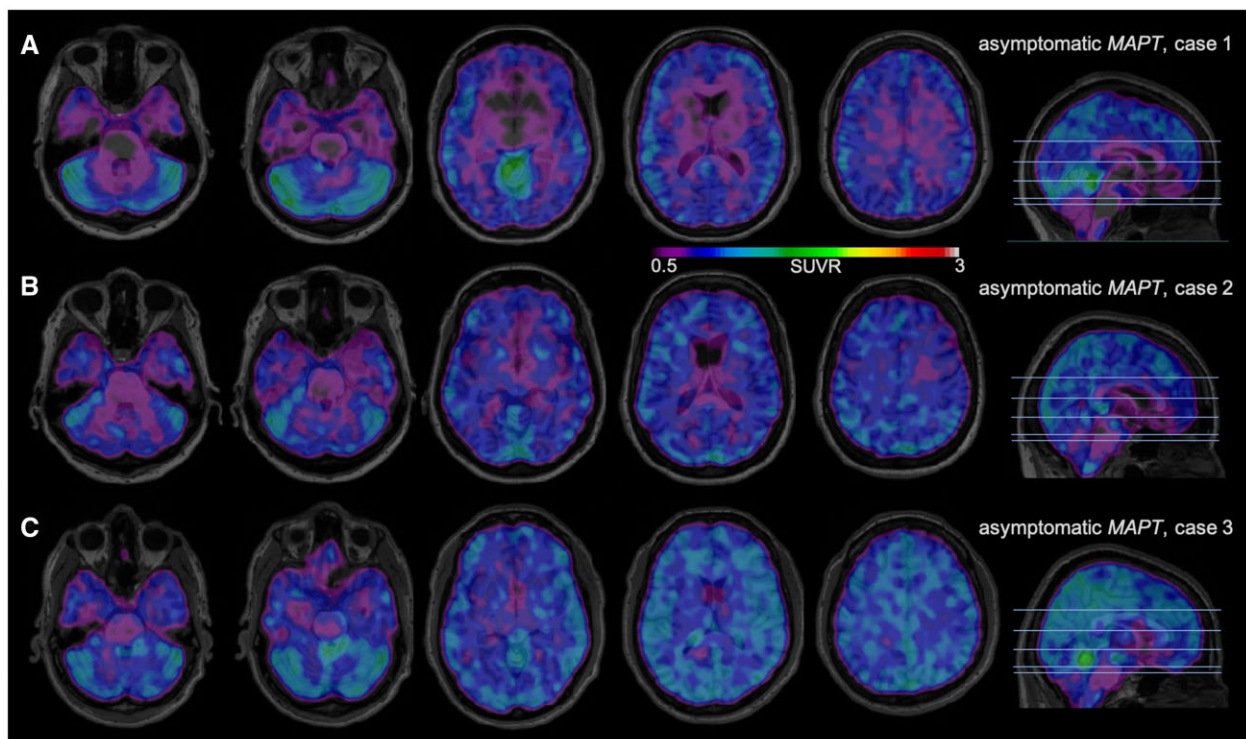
¹⁸F-MK-6240 tau-PET scans in presymptomatic MAPT mutation subjects. A higher SUVR represents stronger binding. Binding to meninges, including the tentorium cerebelli, is considered to be off-target. Scans are masked to minimize off-target binding to meninges. (A) A 30-year-old male with asymptomatic P301L MAPT mutation, estimated years to onset (EYO) 30, MMSE 29/30. (B) A 57-year-old male with asymptomatic P301L MAPT mutation, EYO 1, MMSE 29/30. (C) A 52-year-old male with asymptomatic P301L MAPT mutation, EYO 5, MMSE 28/30.
